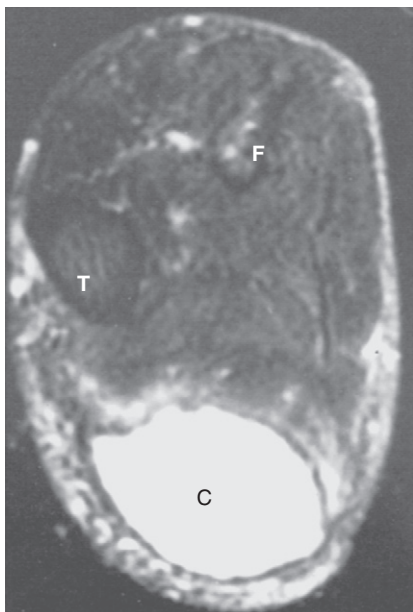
Magnetic resonance image shows a high T2 signal intensity, large, oval-shaped synovial cyst that extends from the knee joint into the posterior calf. C, synovial cyst; F, fibula; T, tibia.
